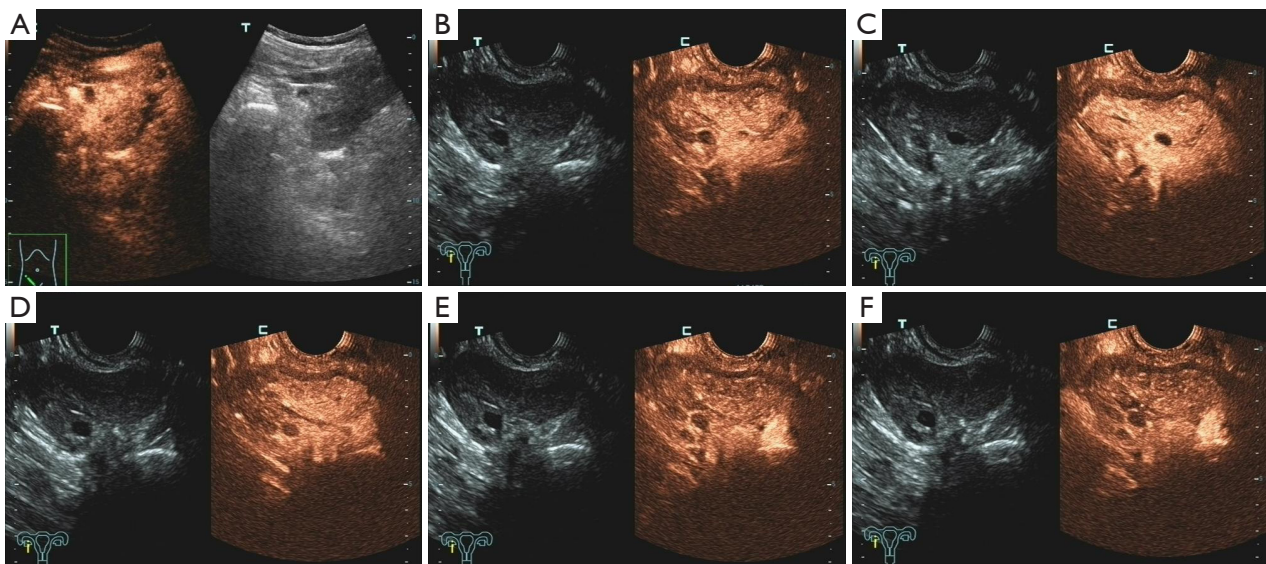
CEUS findings of the ovarian mass at the following different time points: 23 (A), 24 (B), 25 (C), 26 (D), 40 (E), and 52 s (F). CEUS, contrast-enhanced ultrasound.
